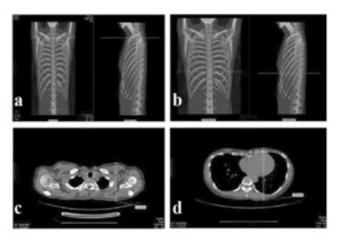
Measurement of the chest length at rib 2 (a and c) and rib 6 (b and d) using computed tomography
